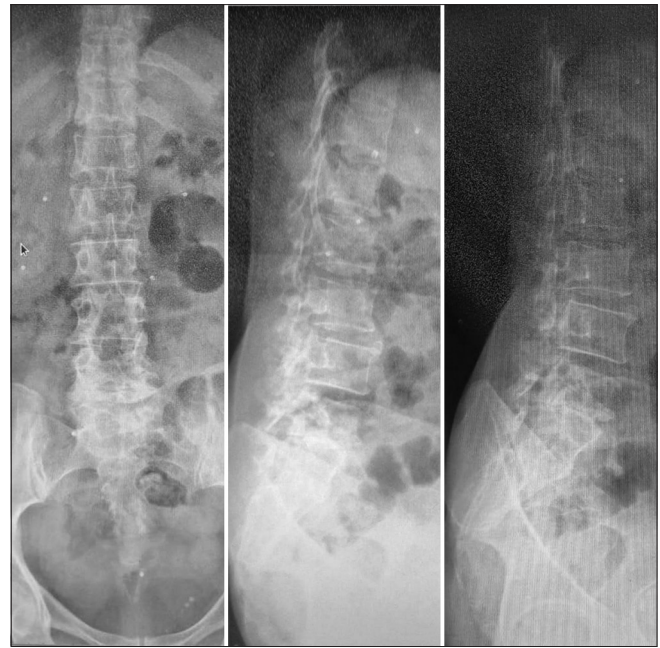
Pre-operative X-rays showing mild retrolisthesis of L3 over L4
